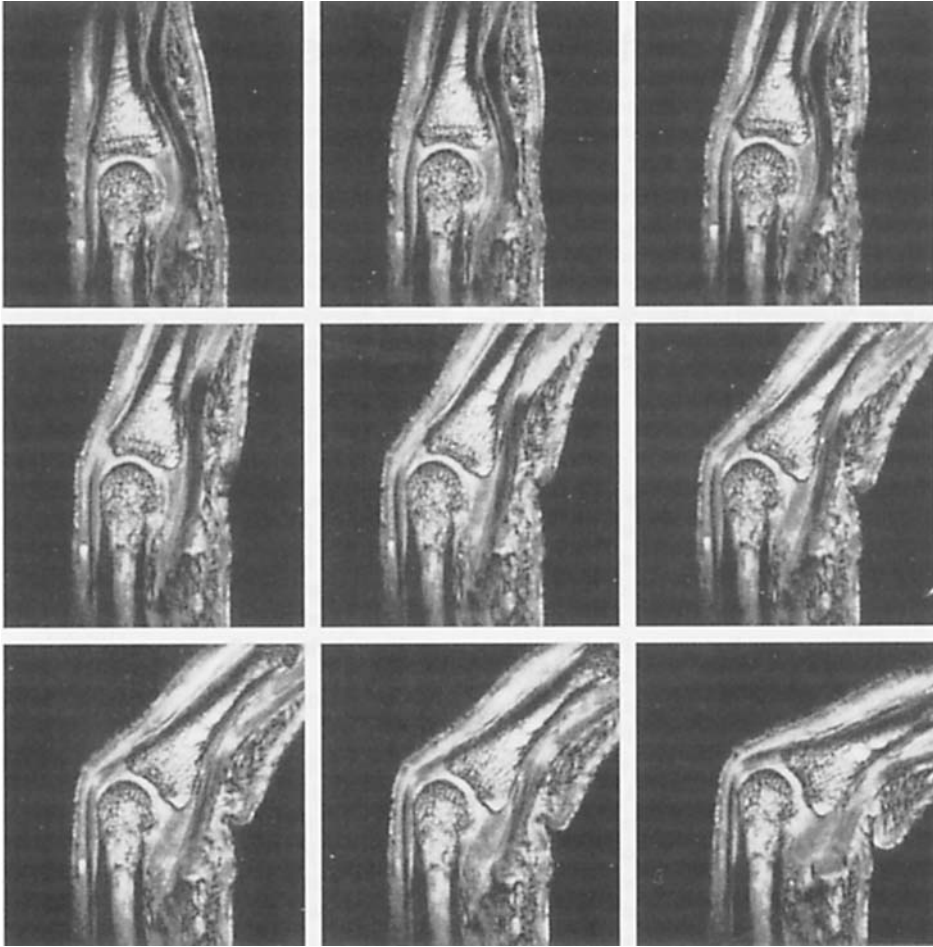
MR images of the index finger of an 25-year-old man, showing 9 different stages of flexion.
